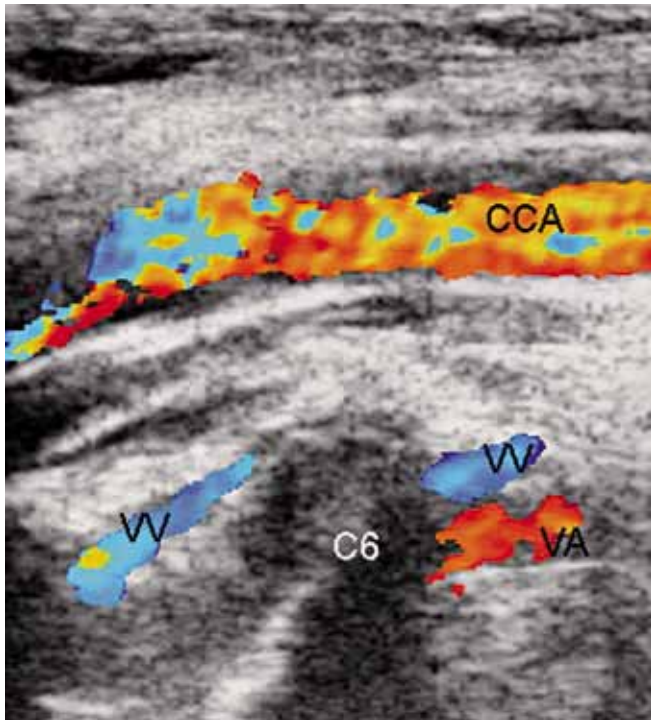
Example of color-Doppler vertebral vein assessment.
